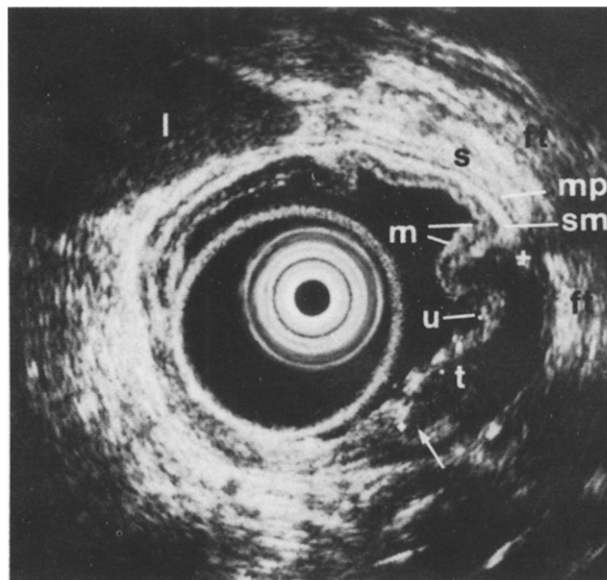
Endoscopic ultrasonography, corresponding with Fig. 4, shows the polypoid lesion as a sharply demarcated hypoechoic echo pattern directly adjacent to an ulcerative lesion (U). Note the clear transition between the normal and pathological gastric wall (m = mucosa, sm = submucosa, mp = muscularis propria, s = subserosa, ft = fat tissue and l = liver).
